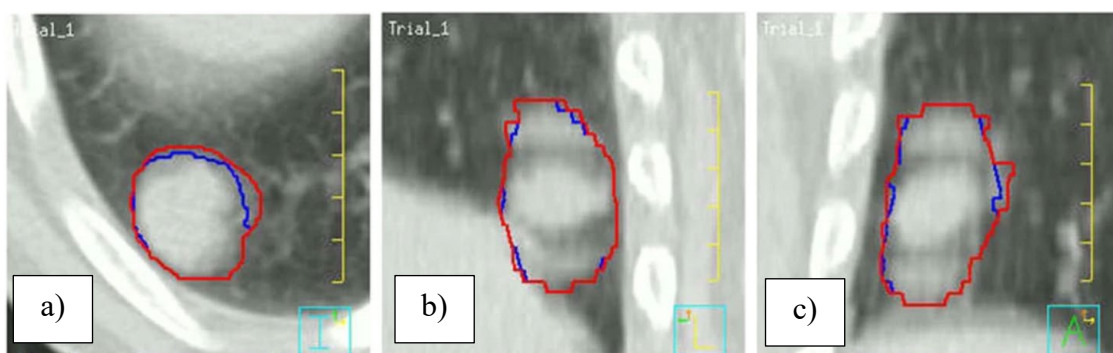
The (a) axial, (b) sagittal and (c) coronal views showing the projection of ITV_{all} (blue) and $\text{ITV}_{\text{all+slow}}$ (red) on a modified slow CT scan, comparing between both volumes. (Adapted from Jang et al., 2014)
